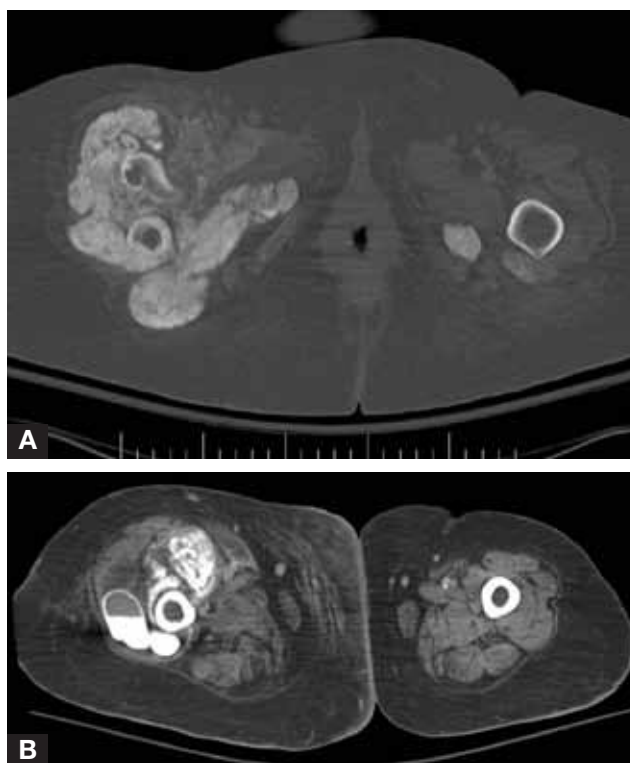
(A) Bone-window computed tomographic image shows fracture of proximal femur with surrounding calcified lesions within soft tissues. (B) Similar computed tomographic image shows fluid-calcium level within one of these lesions.
